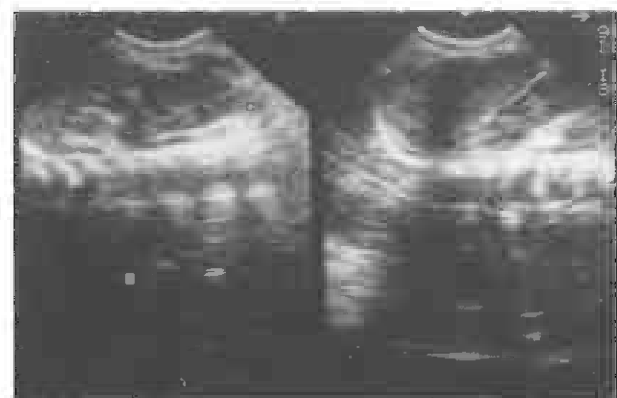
Follow up sonogram of the same suprarenal mass with a rim of calcification
